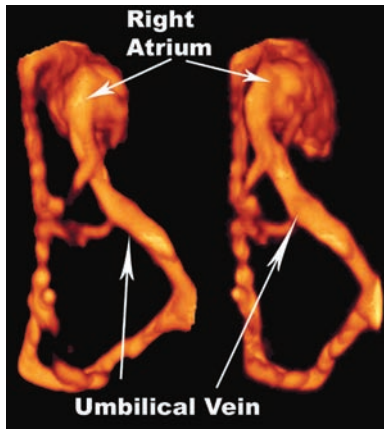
Power Doppler rendered volume of a fetus at 20 weeks' gestation with Noonan syndrome. Note the absence of ductus venosus and the umbilical vein draining directly to the right atrium. Note the distorted angio-architecture as compared to the normal fetus in Figure 46.4.
